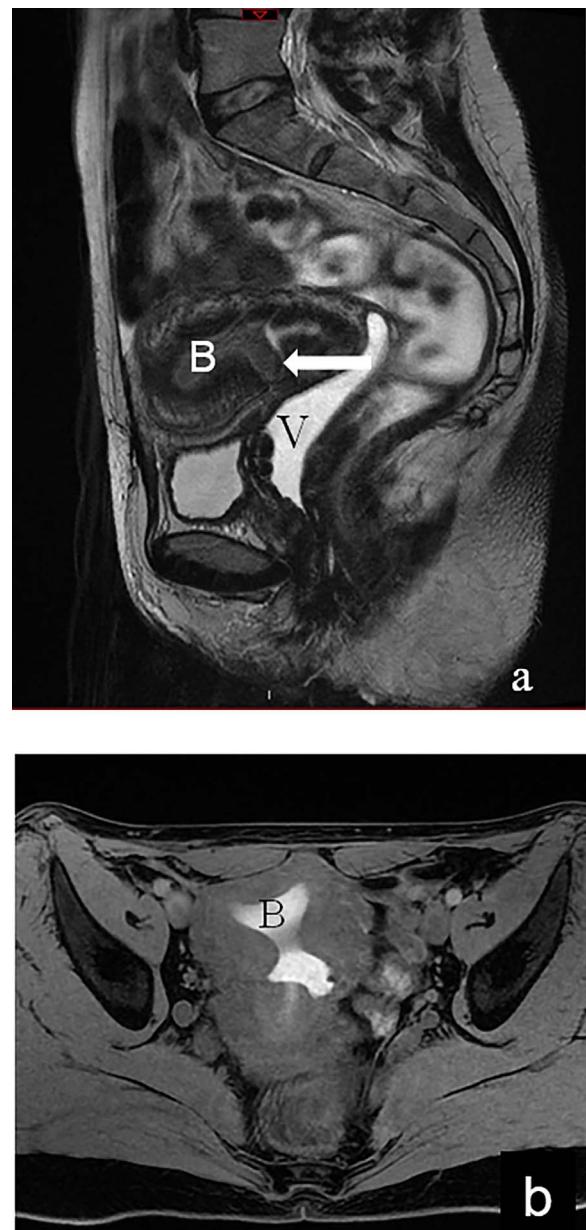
Chronic uterine scar rupture with formation of a “niche”.- 38 y.o. patient with 3 previous cesarean sections presenting abdominal pain and persistent vaginal spotting. Sagittal (a) T2-W MR images and axial (b) FS T1-W MR image show a semicircular defect of the ventral uterus wall at the level of the isthmus (white arrow). The cavity is filled with hematic fluid (B), also present at the cavum uteri. Menstruation normalized after surgical correction. V = Vagina.
